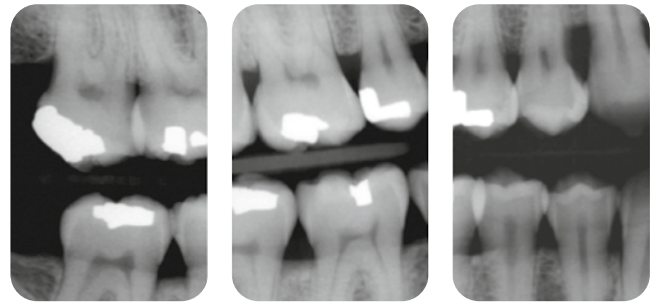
Vertical bitewings following six months of healing.
